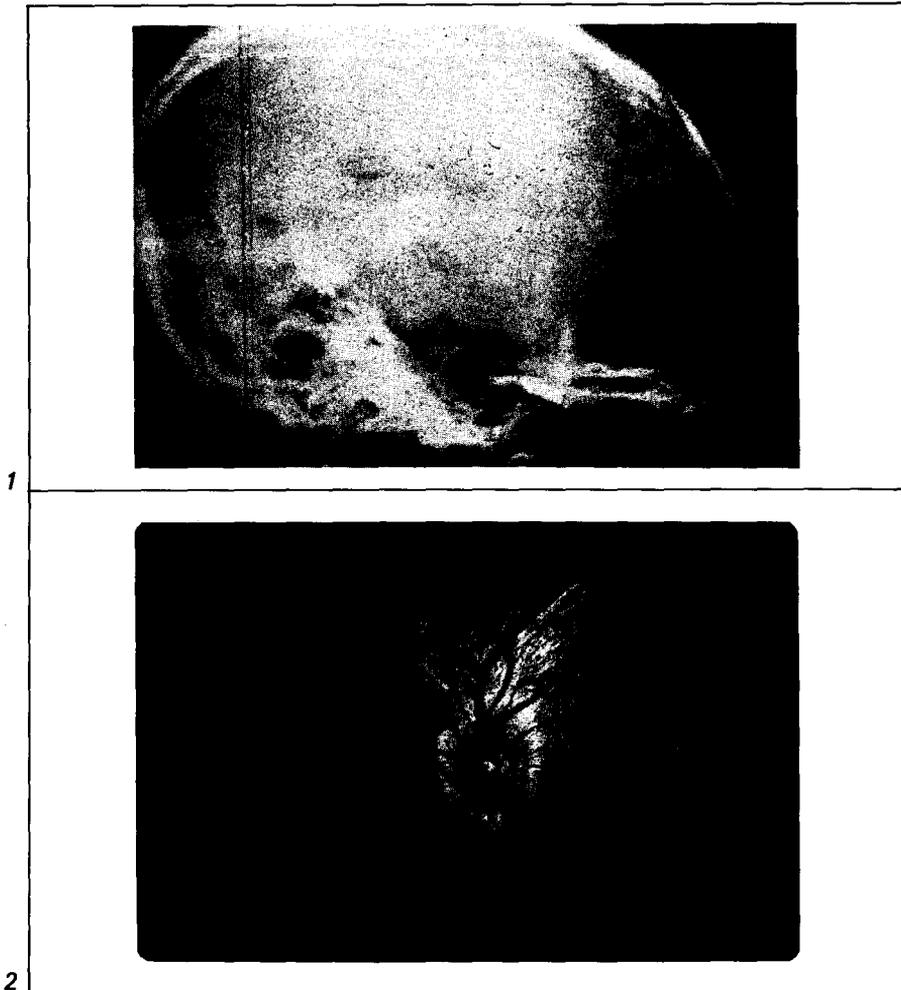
Plain skull x-ray showing the 'ballooned' pituitary fossa with approximation of the anterior and posterior clinoid processes — the 'closed' configuration.
